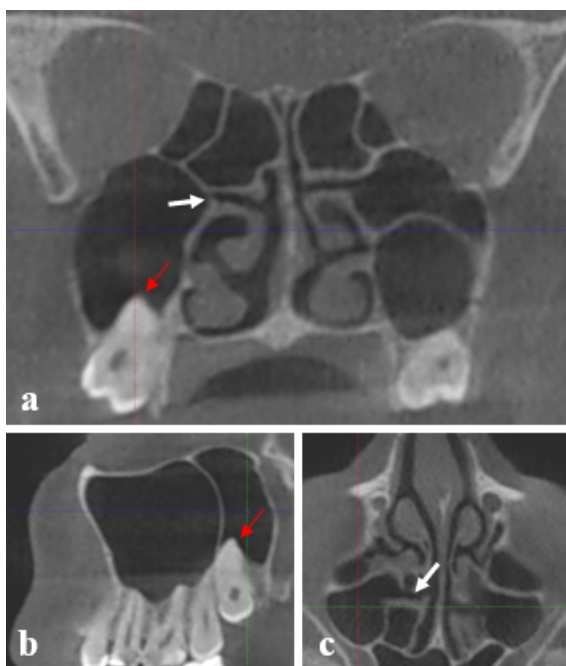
CBCT, coronal (a), sagittal (b) and axial (c) scans demonstrating right ethmomaxillary sinus extending to the alveolar process. White arrow shows drainage to superior nasal meatus, red arrow shows the root of third upper molar protruding into ethmomaxillary sinus
